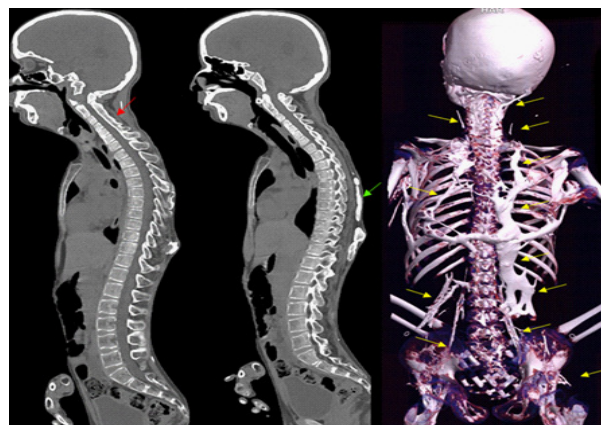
(a) CT (Bone window) whole spine in sagittal view show C2-C7 facet joint fusion (red arrow), (b) irregular ossification foci in the superficial soft tissue of the dorsal region (green arrow), (c) 3-D VRT image in posterior view shows the extent of heterotopic ossification from occiput to pelvifemoral junction traversing through soft tissues of thorax and back (highlighted by yellow arrows).
